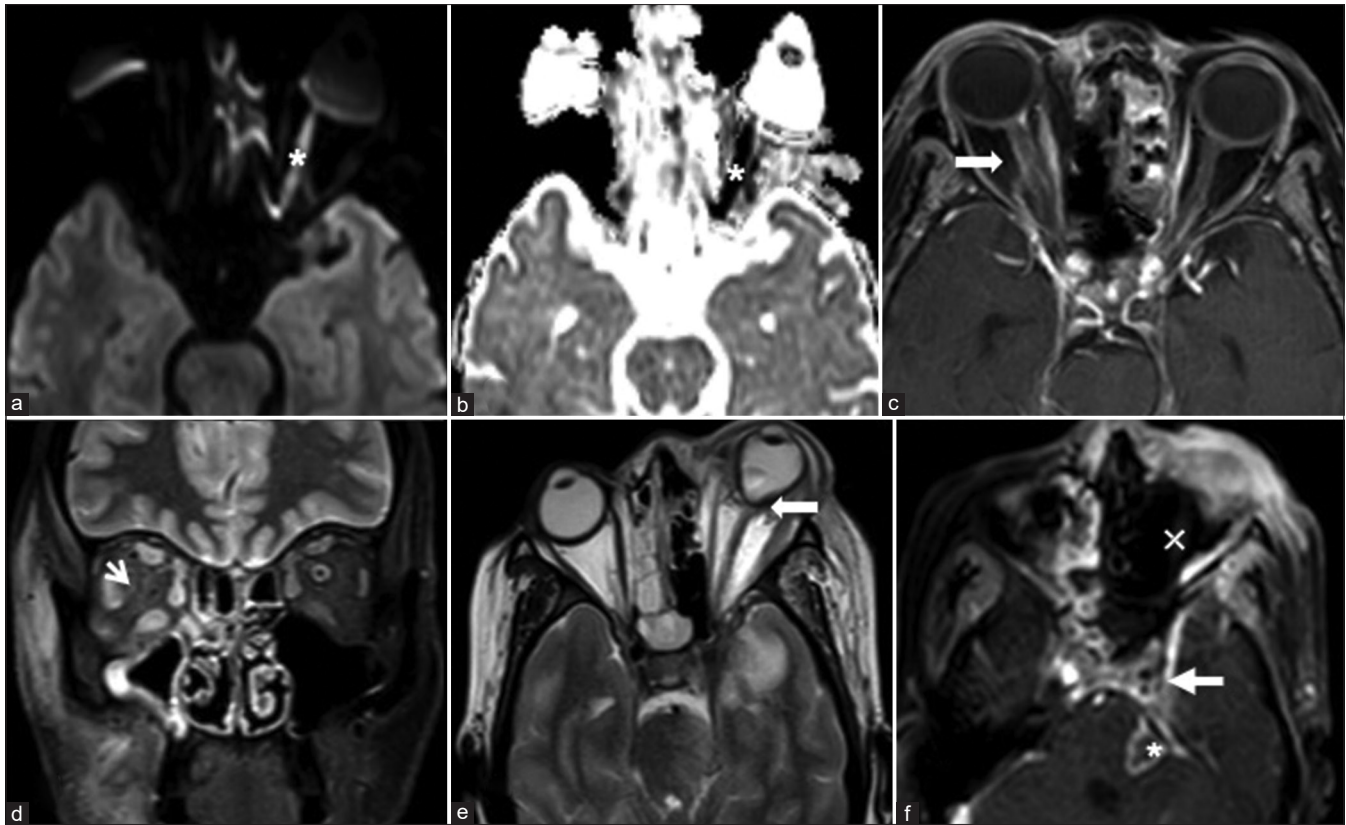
(a and b) DWI (a), and ADC map (b) diffusion restriction* in left optic nerve. (c) CE T1W FS image: enhancement and thickening of the right optic nerve (arrow) and sheath. (d) T2W FS image: fat stranding in right orbit with hyperintense EOMs, loss of perioptic CSF sleeve (arrow) suggesting orbital cellulitis and optic nerve involvement. (e) T2W image: guitar pick sign (arrow). Left medial temporal lobe changes suggest encephalitis secondary to contiguous involvement from the cavernous/paracavernous disease. (f) CE T1W FS image: left orbital infarction (x), left cavernous sinus thrombosis (arrow), abscess formation in left pons*
